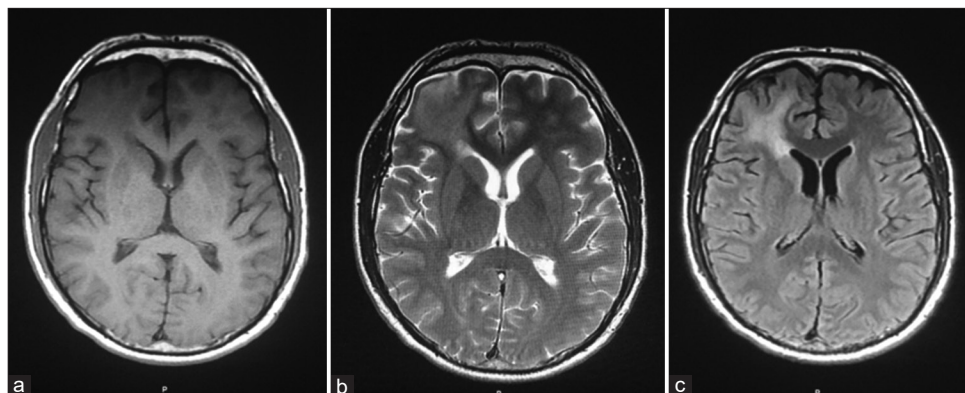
(a) Axial T1-weighted MR image , (b) axial T2-weighted MR image and (c) axial T2-weighted- fluid attenuated MR image.
